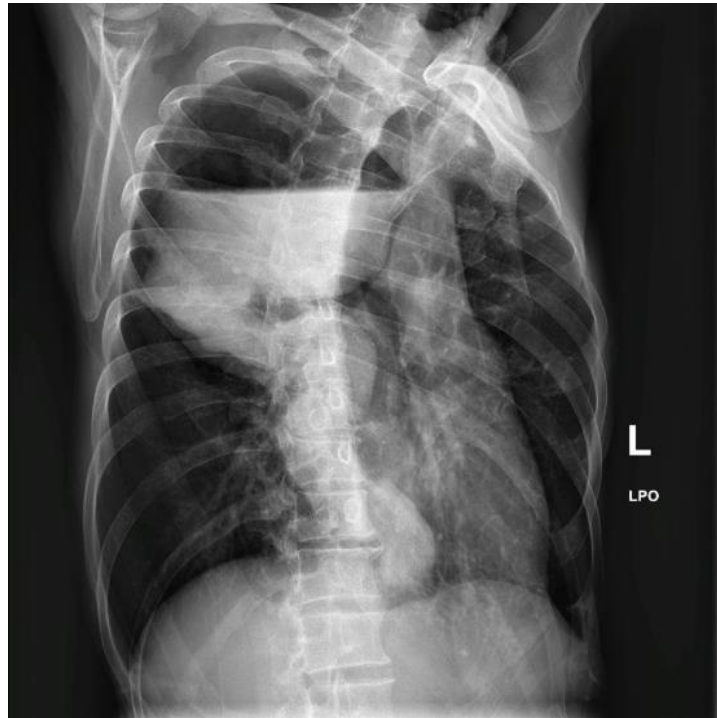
Chest X-ray with contrast, Left Posterior Oblique (LPO) Position
